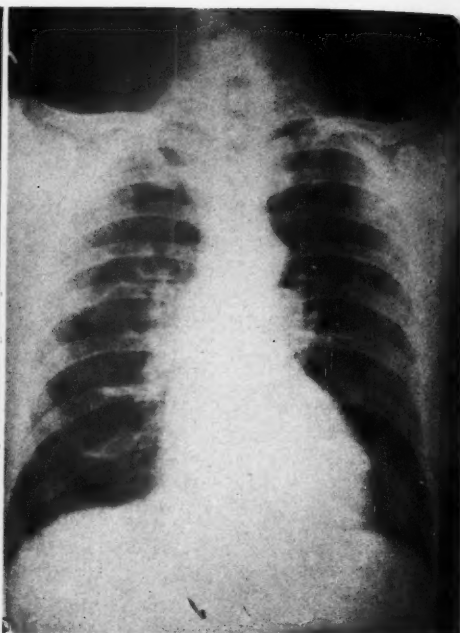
The heart in hypertension shows hypertrophy with variable dilatation of the left ventricle. Note its smooth, rounded contour. The curve of the ascending aorta is accentuated. Roentgenoscopically the amplitude of contractions is increased in the region of the ventricle and aorta.
